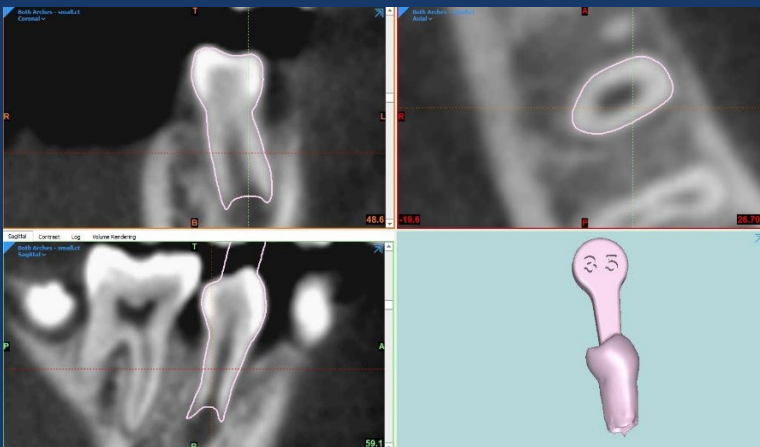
CBCT images used to print out surgical 3D models of intended donor teeth
